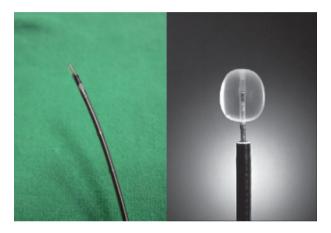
Radial Probe Endobronchial Ultrasound. Left, probe and deflated balloon. Right, probe within a bronchoscope with balloon inflated.
